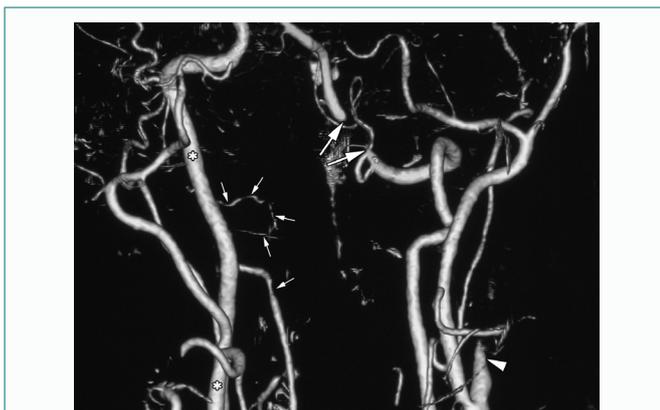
A 3D CTA image showing an occlusion of the initial part of the left internal carotid artery (arrowhead), an occlusion of the dural segment of the left vertebral artery (between the two larger arrows), and an irregular luminal narrowing of the hypoplastic right vertebral artery (smaller arrows). The cervical part of the right internal carotid artery is labeled by an asterisk (*).
